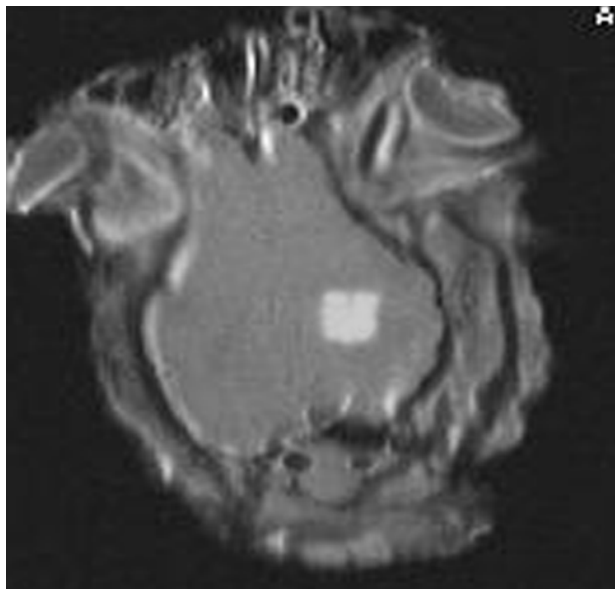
MRI image using T1-w FSE of large thermal lesion created *in vivo* using 2000 W/cm² for 20 s.
